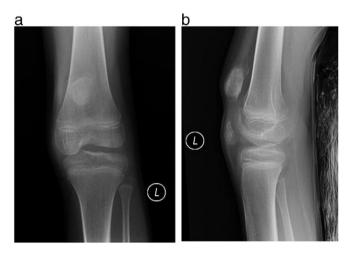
Anteroposterior (a) and lateral (b) view radiographs taken at time of presentation to our institution, six months after the initial injury. Demonstrated is a 23-mm gap between the patella and the ossified patellar sleeve fracture fragment.
